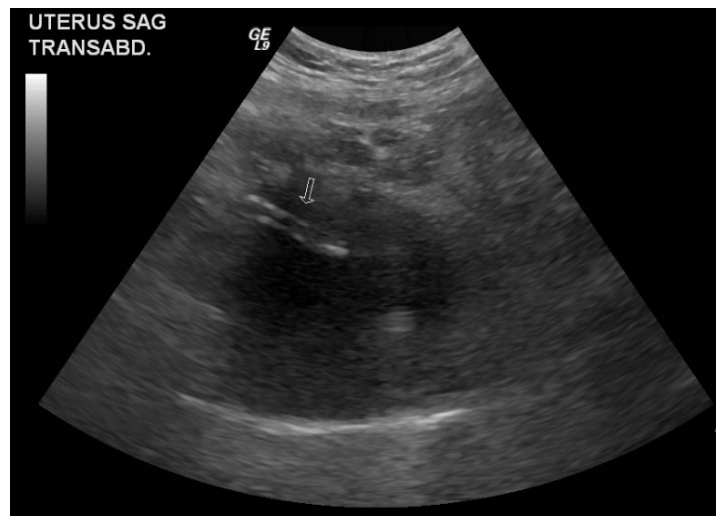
Transabdominal ultrasound image showing a foreign object within the uterus.
